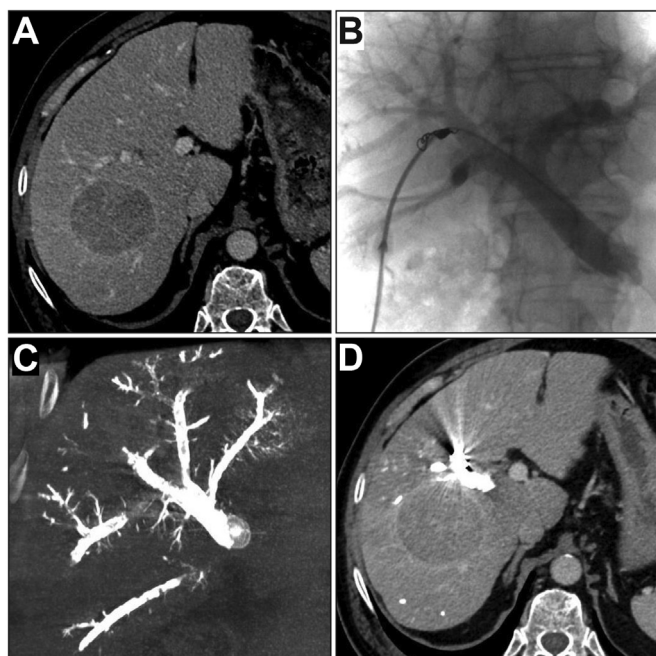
66-year-old man with cirrhosis secondary to non-alcoholic fatty liver disease complicated by hepatocellular carcinoma. (A) Preoperative contrast-enhanced CT shows a 6 cm hepatocellular carcinoma. The future liver remnant was 27%. (B) Angiography shows right portogram after ipsilateral canalisation of the portal vein. Embolisation was performed with a mixture of N-butyl cyanoacrylate and lipiodol. One small anterior branch was coil embolised to avoid embolisation material migration (C) Cone beam CT angiography after portal vein embolisation shows embolic agents in the right portal vein. (D) Contrast-enhanced CT 6 weeks after portal vein embolisation shows relative hypertrophy of the left liver. The future liver remnant increased to 41%. Patients underwent successful right hepatectomy.
